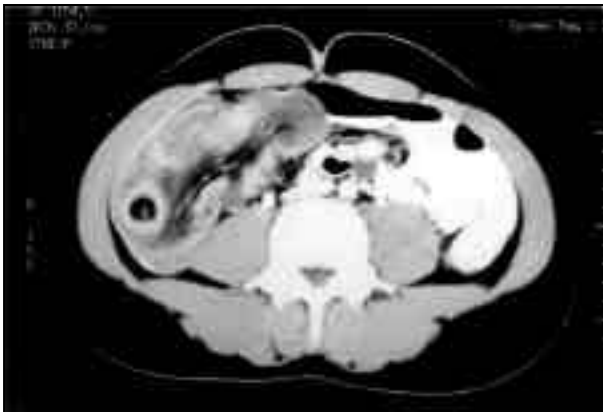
CT showing "reniform" appearance of invaginating ileum and mesentery, with ileo-cecal valve
